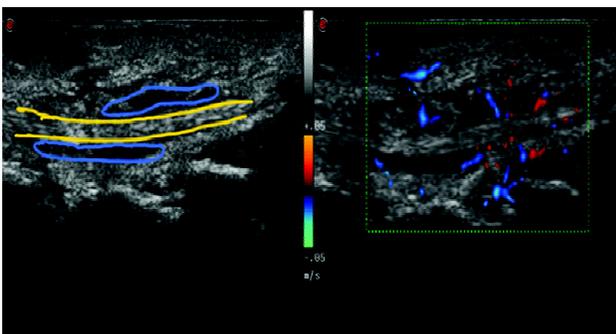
Sonographic image on longitudinal view (on the left) depicting fluid (encircled by blue-line) along the extensor digiti minimi tendon (demarcated as two yellow-lines) and also vascularity on colour map (on the right) suggesting active tenosynovitis.
